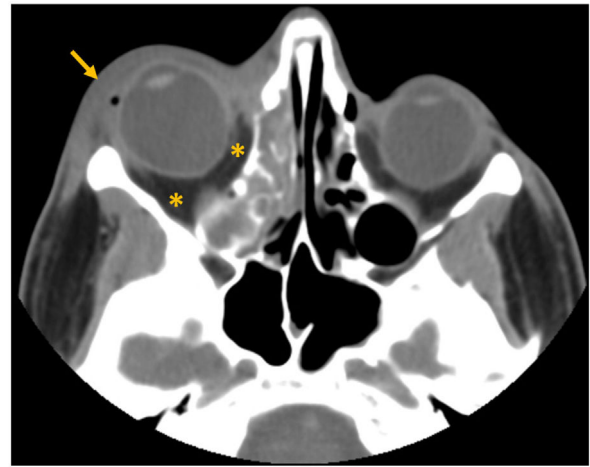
Preseptal cellulitis: Axial unenhanced CT image, soft tissue window, shows thickening and fat densification of the right eyelid (arrow), without any changes in the postseptal (asterisks). Complete opacification of the right ethmoidal cells is also seen, confirming the clinical diagnosis of acute rhinosinusitis.
